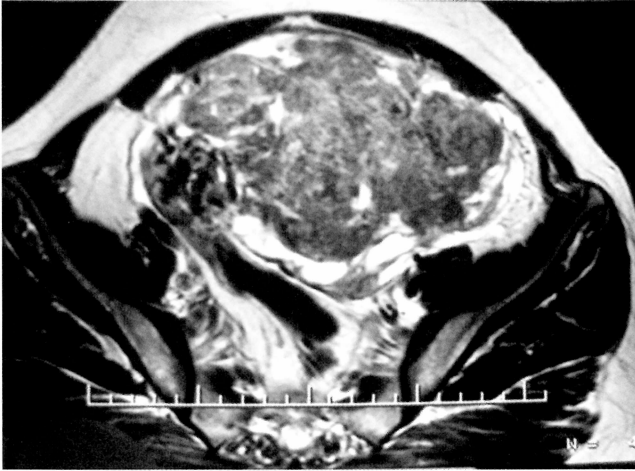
Magnetic resonance imaging scan showing a 16 x 13 cm mass covering the entire pelvis and extending up to the umbilicus.
